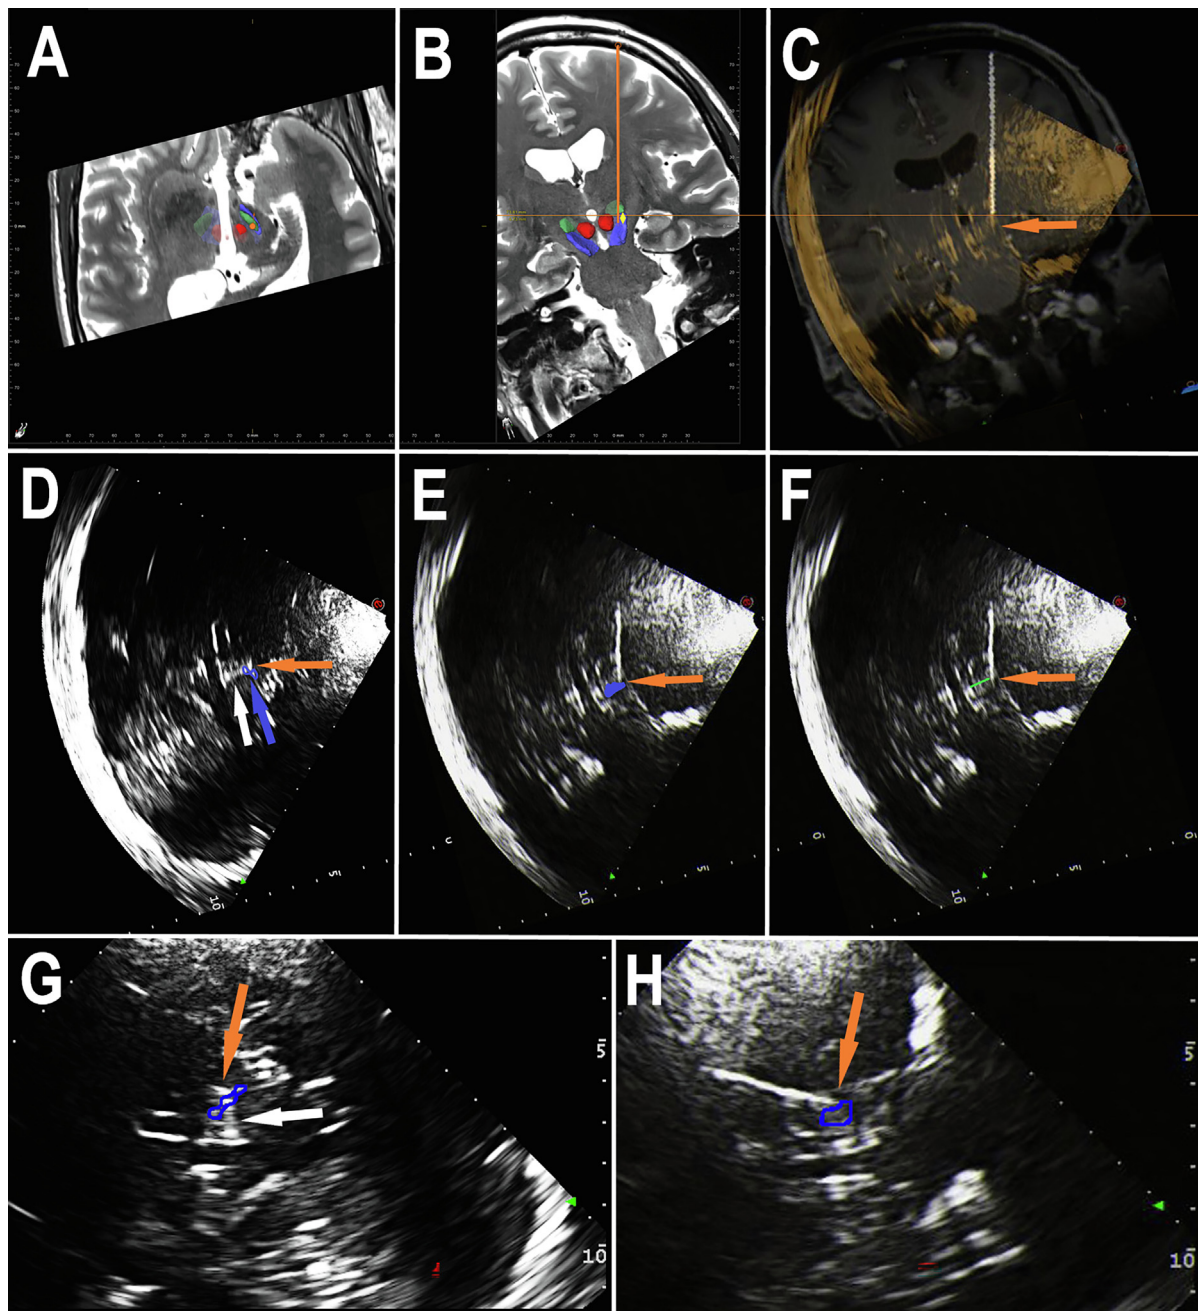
Comparison of electrode location on transcranial sonography (TCS) versus multimodal neuroimaging. In this patient, the permanent subthalamic nucleus (STN) stimulation electrode was inserted through the central (i.e. the preoperatively planned) trajectory. Images shown in (A)–(F) are scaled according to the electrode position. A) Fusion image (Elements, Brainlab) of axial preoperative MRI (STN highlighted in green; substantia nigra [SN], blue; red nucleus, red) with the superimposed electrode position (orange) documented on postoperative CT at the level of the preoperatively planned stereotactic target depth. B) Fusion of coronal preoperative MRI (STN, green; SN, blue; red nucleus, red) with the superimposed electrode position (orange) documented on the postoperative CT. Note that the final electrode positioning based on intraoperative recordings was slightly deeper than planned preoperatively, due to the more caudal localization of the STN assessed on intraoperative microelectrode recordings (yellow rhombus). C) Postoperative real-time TCS-MRI fusion imaging using the preoperative MRI volume data set with tracing of the planned electrode trajectory (Elements DICOM Burned-In Export, Brainlab). The tip of lowest electrode contact visualized on ultrasound (arrow) is located slightly deeper than planned preoperatively, in agreement with the CT-MRI fusion image (B). D) Axial TCS image corresponding to the CT-MRI fusion image (A); orange arrow: transection through electrode; blue arrow: echosignals of SN (surrounded by blue line); white arrow: reverberation artefacts caused by the electrode. E, F) Coronal TCS image corresponding to the fusion images (B, C); arrow: lower boundary of the lowest electrode contact. SN echosignals are highlighted in blue (E). The distance measure between electrode tip and midline is highlighted in green (F). G, H) Zoomed TCS images (G: axial, H: coronal) as displayed on the ultrasound monitor, corresponding to images in (D)–(F); orange arrow: tip of the electrode; white arrow: reverberation artefacts caused by the electrode; SN echosignals are surrounded by blue line.
